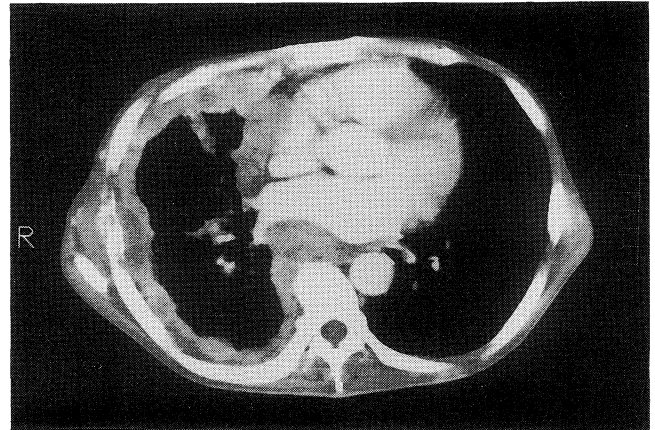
Chest CT on admission showing diffuse pleural thickening on the right.
